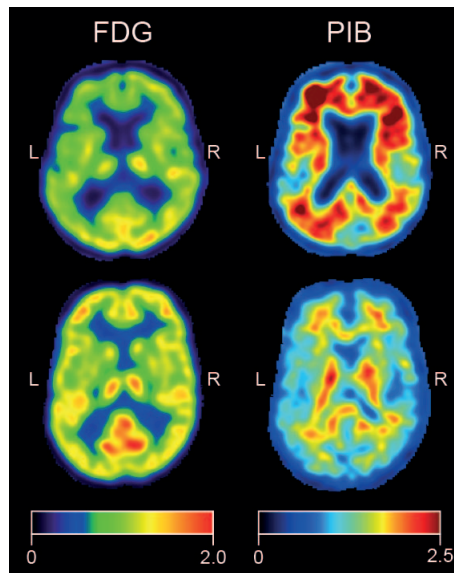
Typical FDG (left column) and PIB (right column) patterns of an AD patient (top row) and an age-matched healthy control (bottom row). Colour scales were adjusted to the same range.
